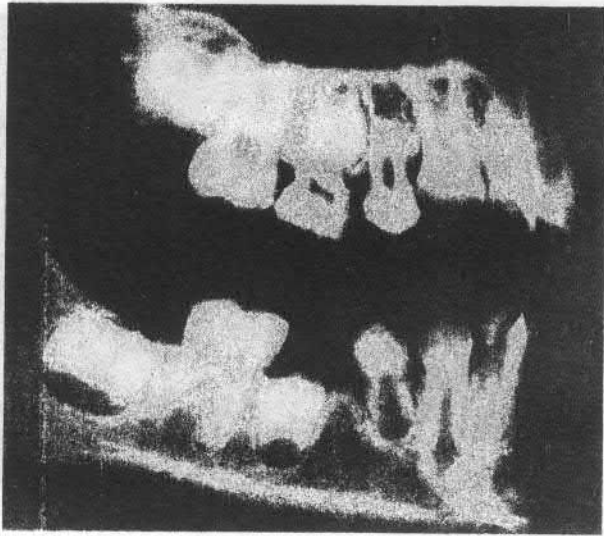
Radiography of maxillaries at the age of 6 years*
